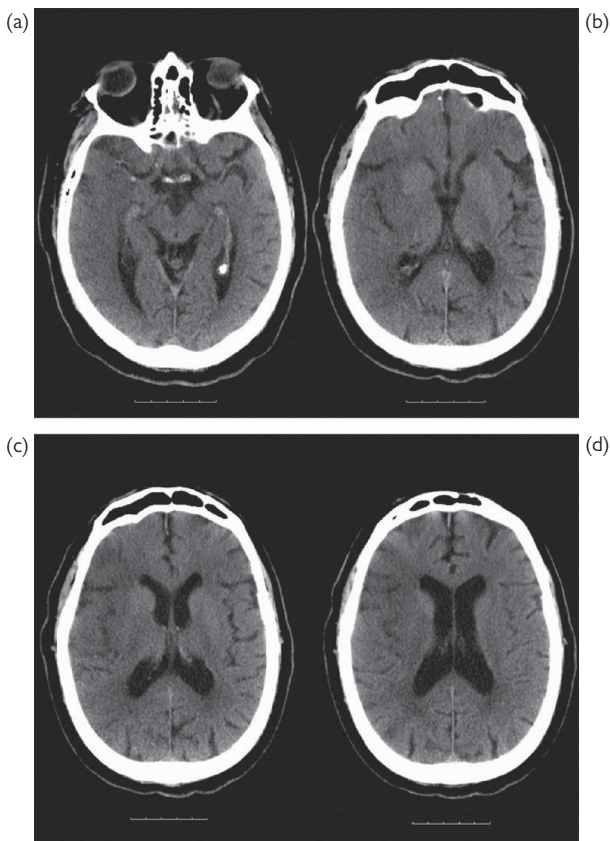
Early CT appearances of a right middle cerebral artery infarct. Low density and loss of tissue definition is seen on all slices. There is loss of sulci and grey–white matter is not so easily distinguished.
